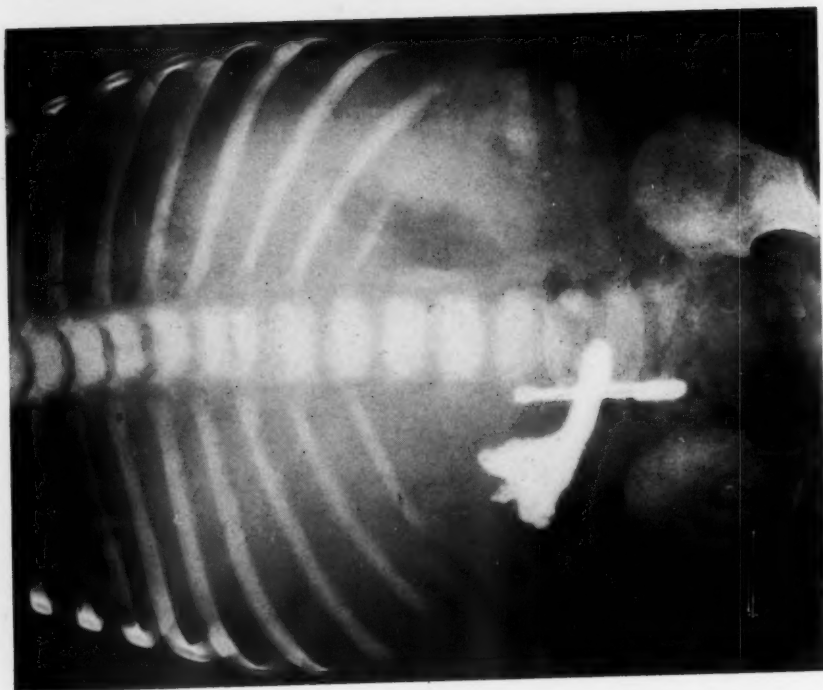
Postoperative roentgenogram, October 8, 1941, following injection of lipiodol through a catheter placed at the point of marsupialization.
